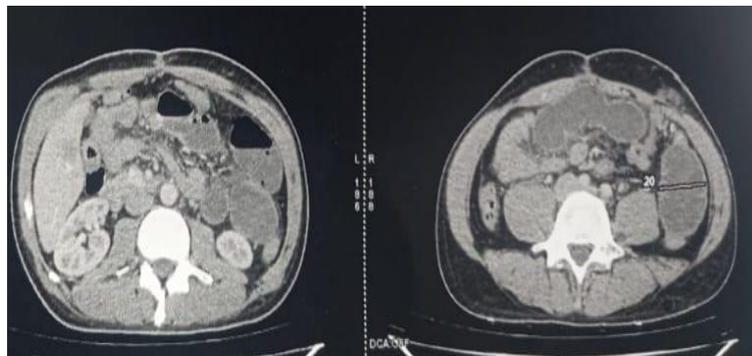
Abdominopelvic CT scan, showing distension and hydroaeric level
